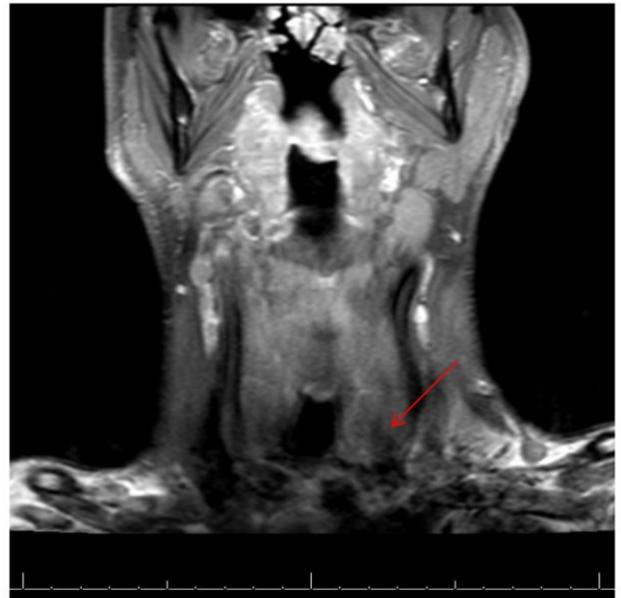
MRI of the Head and Neck, coronal cut, showing hypointense nodule at the left thyroid lobe.
